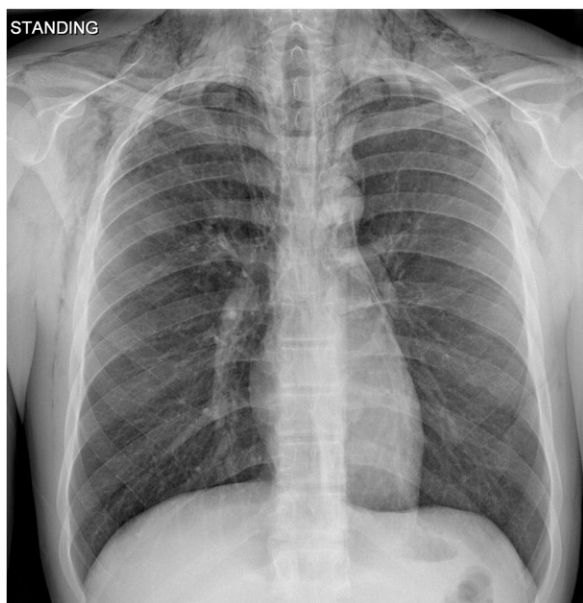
A chest radiograph the day of admission demonstrates subcutaneous emphysema.
